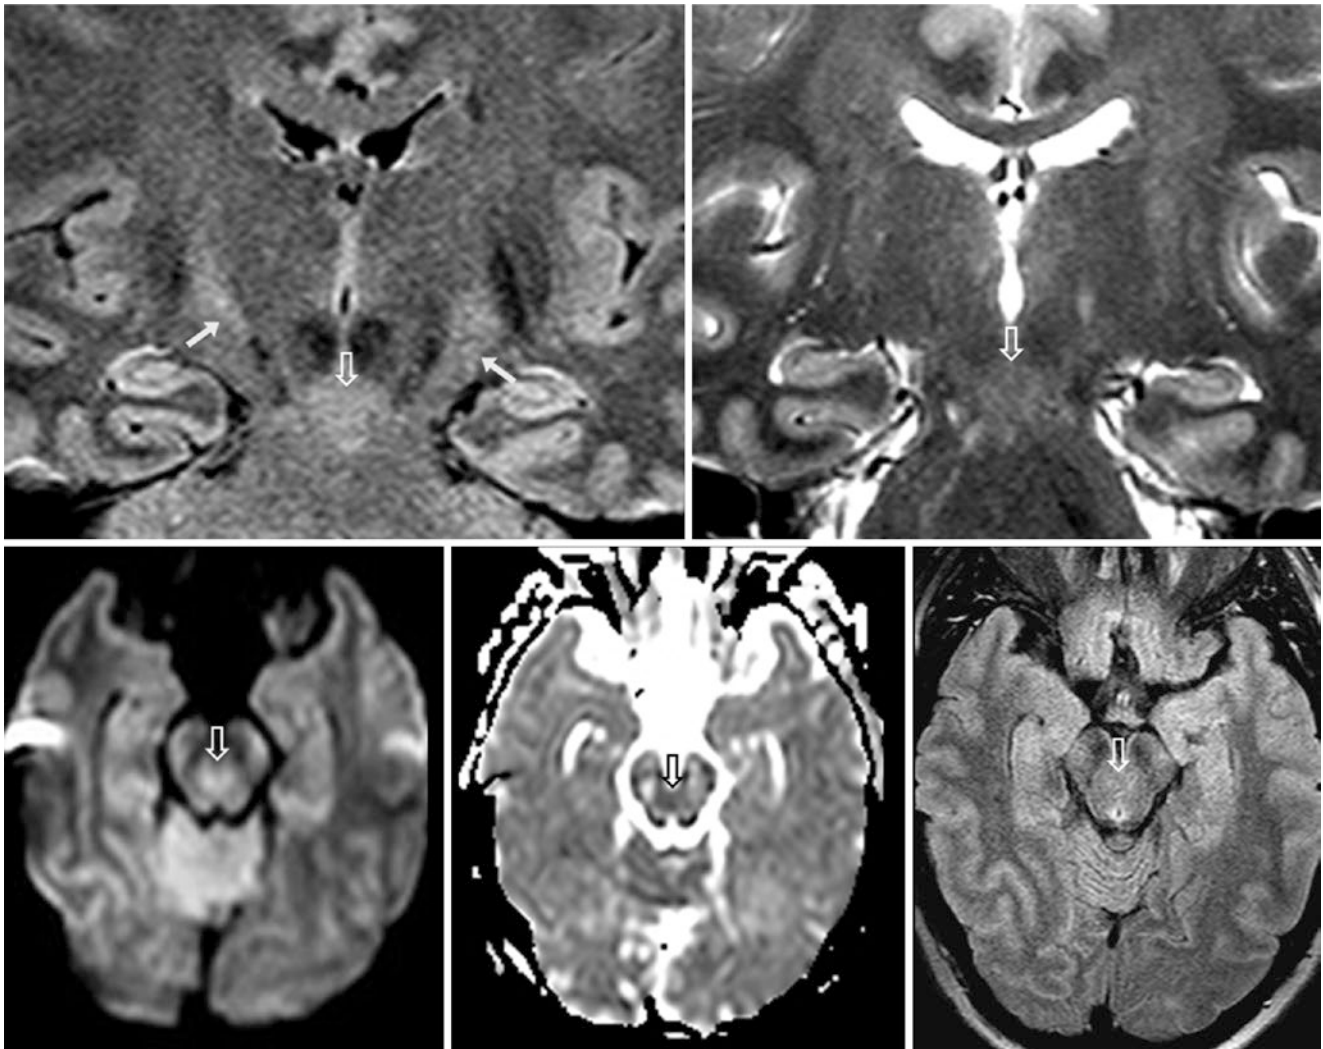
A 37-year-old with a 3 T MRI. Coronal FLAIR (*top left*) and T2WI (*top right*) show mildly bright signal of the DSCP (*open arrows*), which is also mildly hyperintense on DWI (*bottom left*), without corresponding hypointensity on the ADC map (*bottom middle*), or bright signal on FLAIR (*bottom right*). Additionally, there is normal
